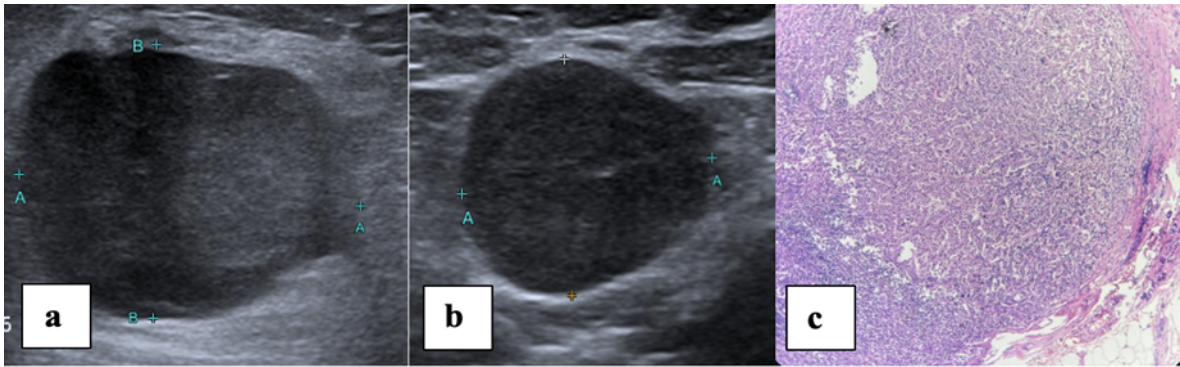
High resolution B mode ultrasound of BI-RADS 4c mass (a), and concentrically thickened lymph node with loss of fatty hilum (b), with HPE (c) of the metastatic lymph node showing metastatic deposit in the subcapsular space in a case of Triple negative molecular subtype of breast cancer
